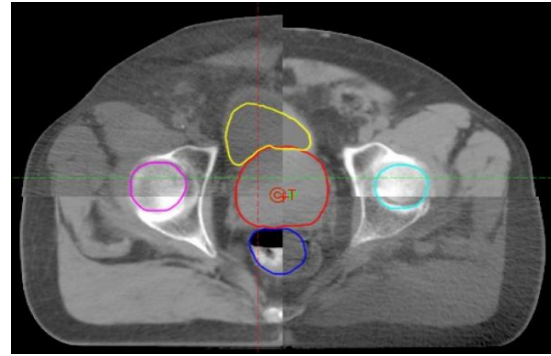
Tissue alignment for CT
